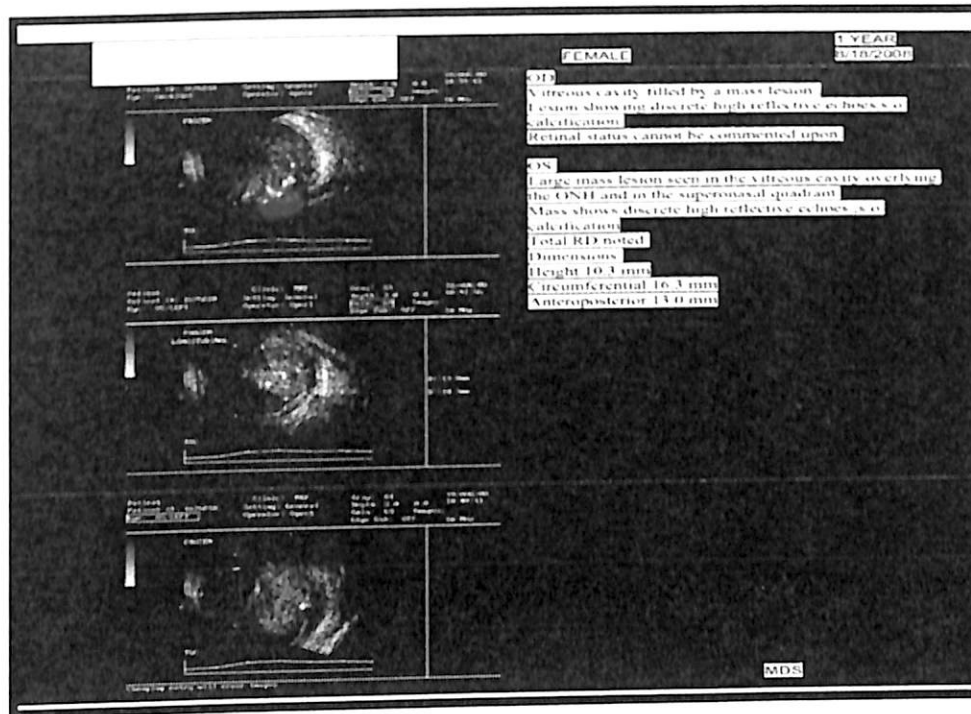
Ultrasound report of RB. Reports the presence of whitish tumor mass in both eyes (Right eye: OD; Left eye: OS).
